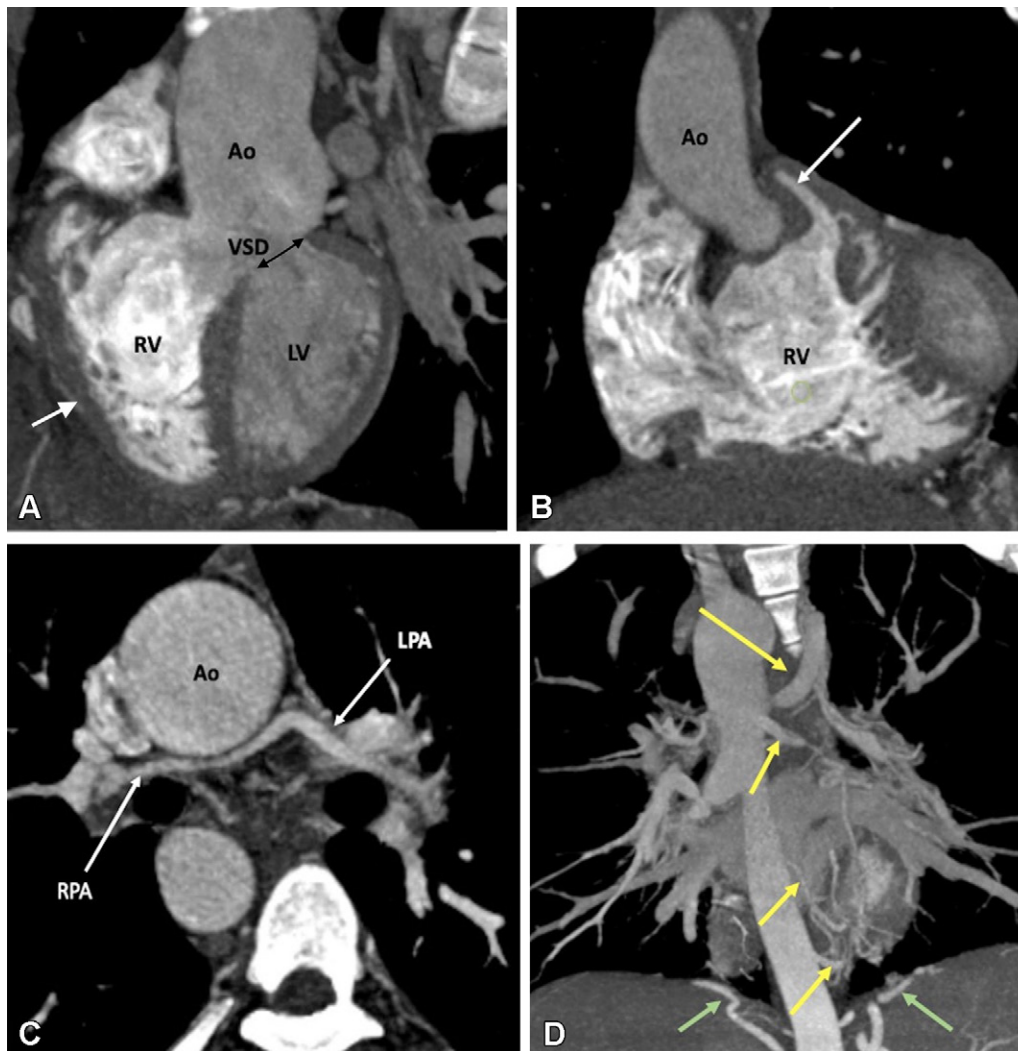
Preoperative appearance of tetralogy of Fallot with pulmonary atresia in a male infant. (A) Sagittal oblique maximum intensity projection (MIP) CT image shows right ventricular hypertrophy (white arrow), VSD (black double arrow), and overriding of the aorta. MPA is not visualized. (B) Coronal oblique MIP CT image shows pulmonary atresia (white arrow). (C) Axial oblique MIP CT image shows severe hypoplasia of the branch pulmonary arteries. MPA is absent. Thin but confluent branch pulmonary arteries produce the typical “seagull wing” appearance. White arrows indicate RPA and LPA. (D) Coronal oblique MIP CT image shows multiple MAPCAs arising from the descending thoracic aorta (yellow arrows) and upper abdominal aorta (green arrows). Ao = aorta, LPA = left pulmonary artery, LV = left ventricle, MAPCA = major aortopulmonary collateral artery, MPA = main pulmonary artery, RPA = right pulmonary artery, RV = right ventricle, VSD = ventricular septal defect.
